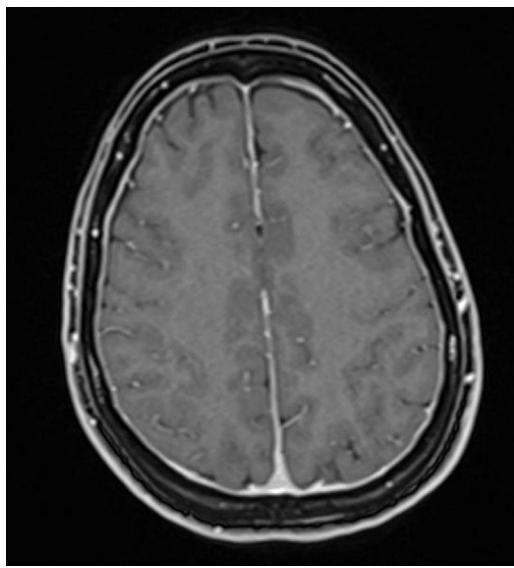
Brain MRI: axial T1-weighted contrast-enhanced sequence showing smooth dural enhancement.
